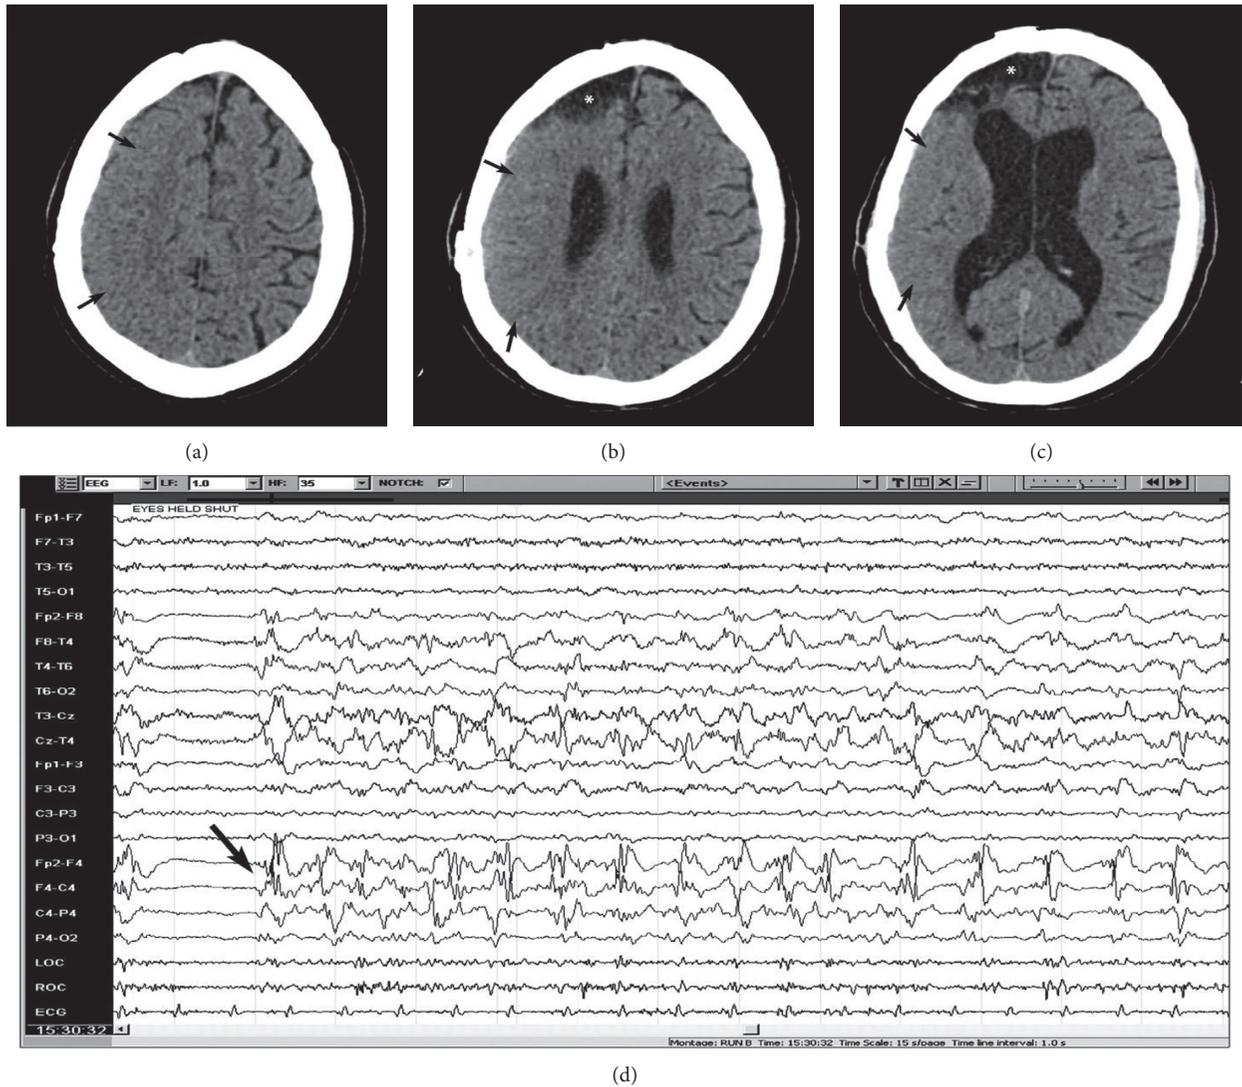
CT scan of the brain without contrast showing acute changes associated with status epilepticus. A middle-aged man with a history of alcoholism and previous traumatic brain injury with surgical intervention resulting in right frontal encephalomalacia presented with recurrent focal seizures consisting of head and eye deviation to the left and left upper extremity clonic activity. He developed new focal weakness of the left upper extremity and left hemianopia that recovered quickly with control of seizures, only to recur few days later with new confusion. An urgent CT scan of the head without contrast showed a large area with effacement of sulci and loss of gray-white differentiation involving the right frontal and parietal lobes (thin black arrows in (a), (b), and (c)), and EEG showed focal right frontal status epilepticus (thick black arrow in (d)). Also note an area of encephalomalacia involving the right anterior frontal lobe (asterisk in (b) and (c)).
